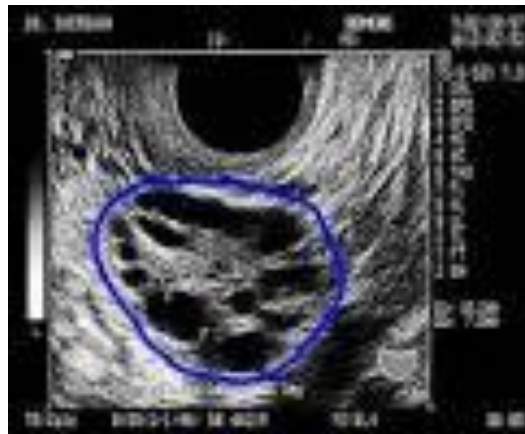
Polycystic Ovary as seen on Sonography
